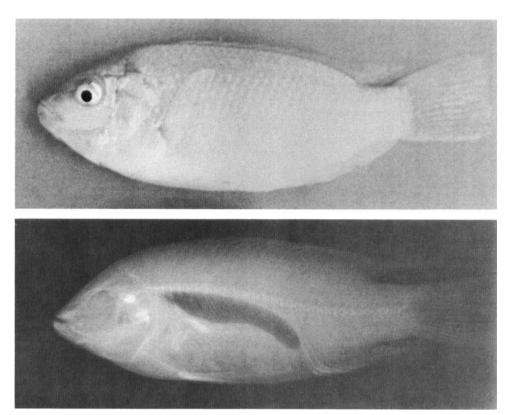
Appearance and radiograph of normal red hybrid tilapia fed a diet containing 5 mg/kg of riboflavin for 8 wk.
